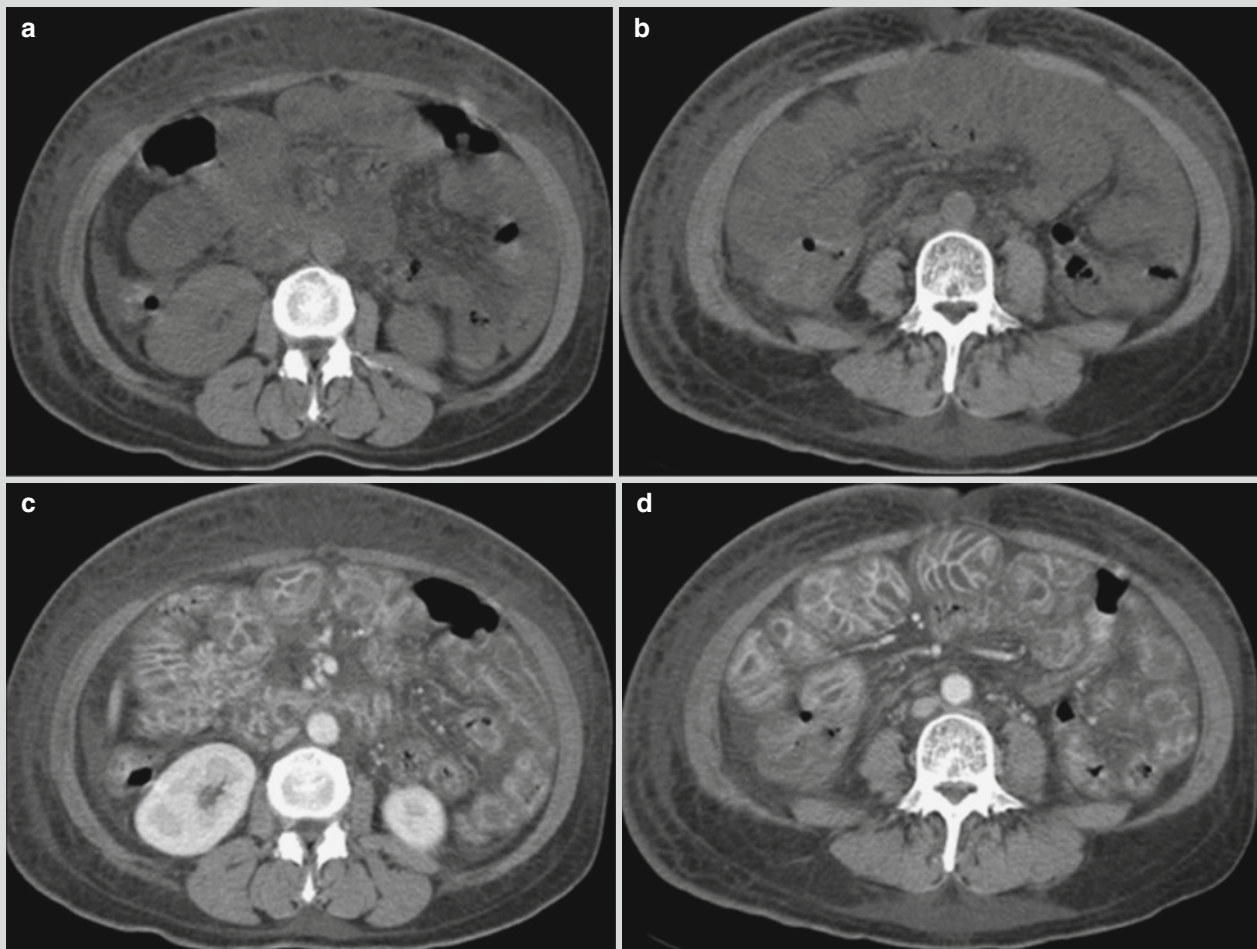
Abdominal wall edema and the intestinal wall of malaria and ascites. (a–d) CT scanning demonstrates extensive swelling of the abdominal wall and the intestinal wall as well as liquid density shadows surrounding the intestinal canal
